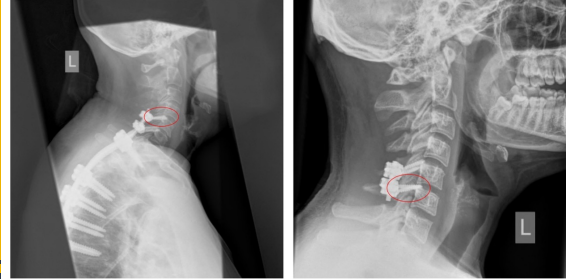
Two plain radiographs showing screws which are too long.
